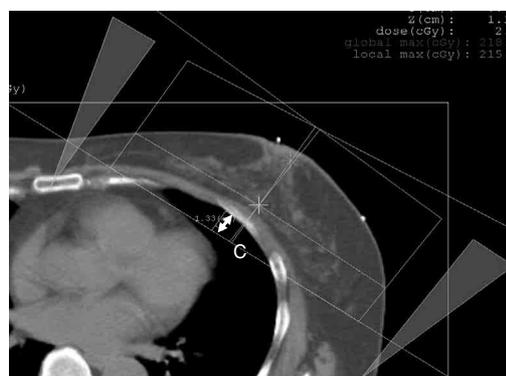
The furthest distance between the posterior border of the radiation field and the chest wall was measured from the axial image of the treatment planning CT. C : central lung distance (CLD) (cm).
